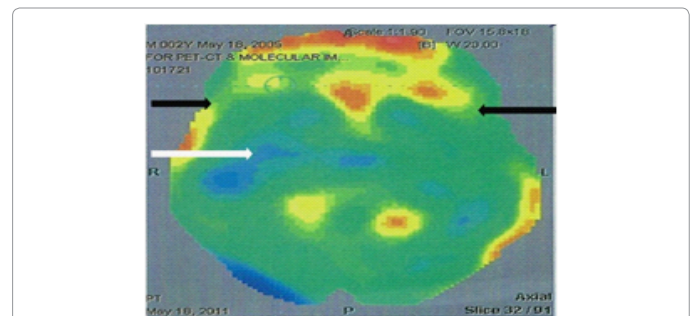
PET-CT scan before the stem cell therapy: Black arrow signifies reduced FDG uptake in the left mesial temporal as compared to the right side. The white arrow signifies reduced FDG uptake in the right basal ganglia seen as blue areas, as compared to the left side which are seen as green areas.
